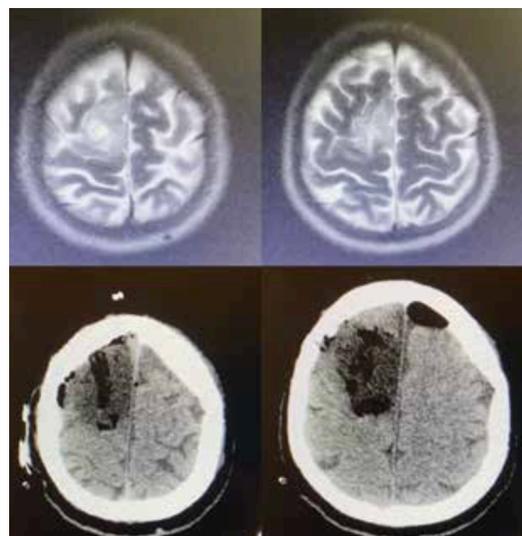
Preoperative MRI and postoperative CT scan
